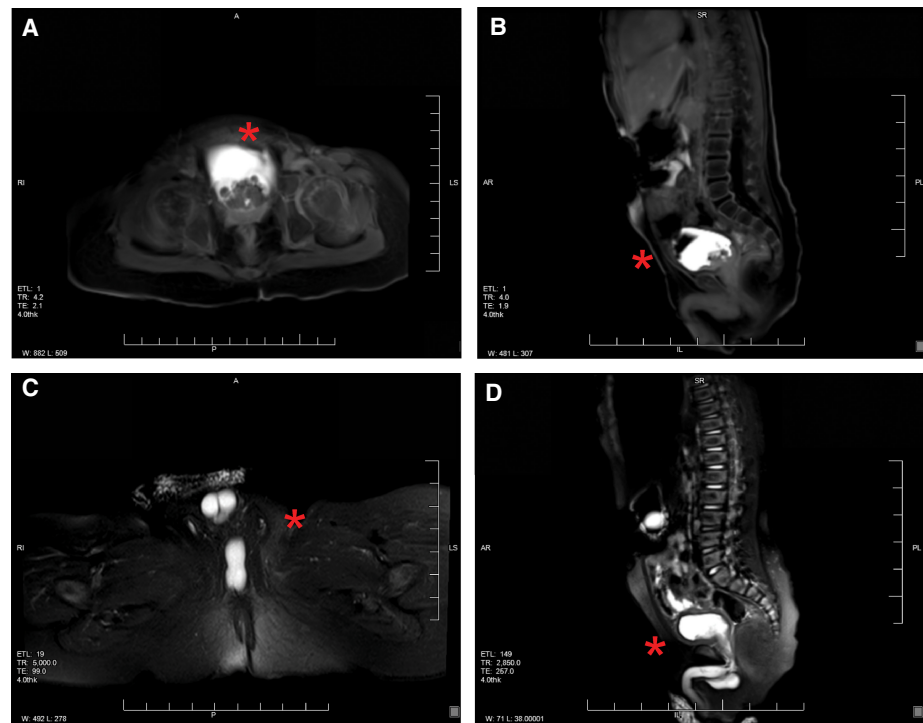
MRI of the abdomen and pelvis. A multilobulated heterogeneous T₂ hyperintense and T₁ isointense intraluminal mass (red asterisk) was found arising from the posterior bladder base with the following sequences: axial T₁ radial VIBE with fat saturation +C on the pelvis (A) and sagittal radial VIBE with fat saturation (B). A T₁ hypointense and T₂ hyperintense lesion ventral to the anterior urethra was found with the following sequences: axial T₂ with fat saturation on the pelvis (C) and sagittal IR triggered (D).
